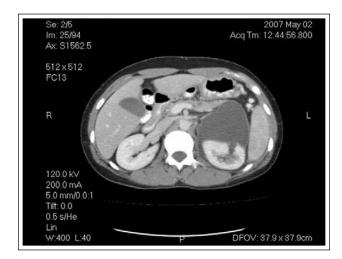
CT scan after administration of IV contrast shows a fluid collection anterior and medial to the left kidney with an associated parenchymal defect.
